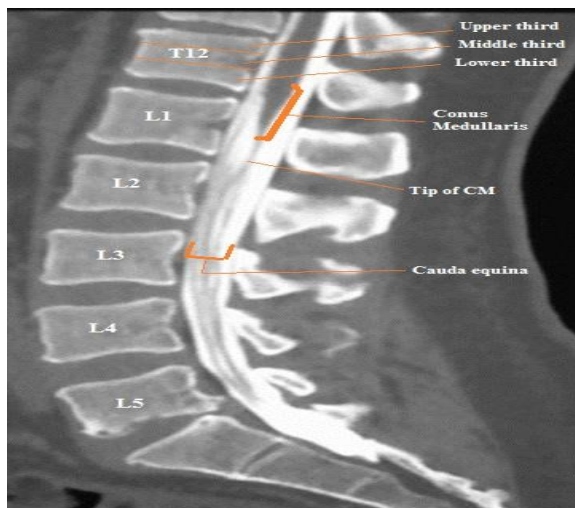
Coronal CT scan of the lumbar spine shows spinal column and vertebrae. Note to position of conus medullaris and cauda equina in spinal canal.
